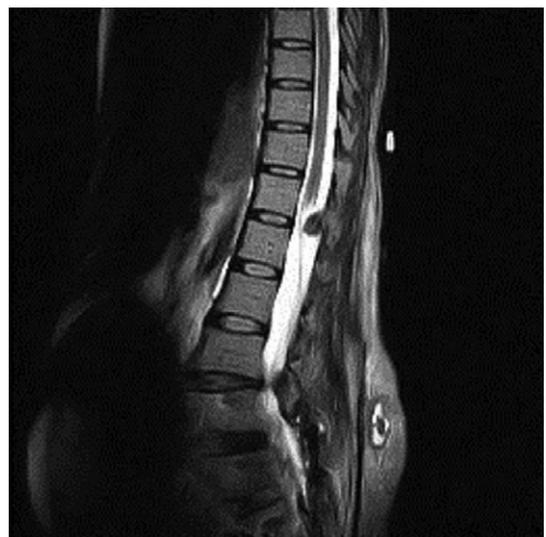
Granuloma at L1-L2 as seen on magnetic resonance imaging. <Correction added after online publication 11 April 2012: The original figure legend incorrectly identified the granuloma as appearing at T1-T2. The legend has been corrected here.>
